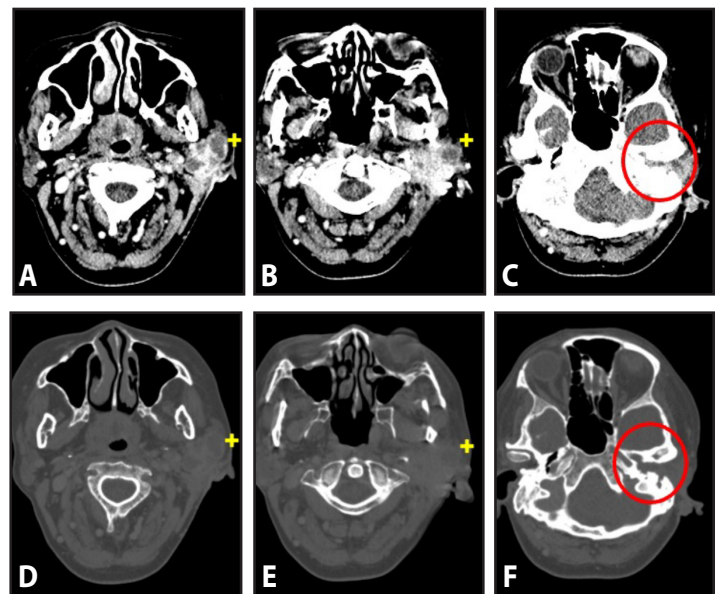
Computed Tomography Scans, axial high resolution: A-C, soft tissue and D-F, bone windows revealing a multiple heterogenous cystic nodule with enhancing wall seen in the left infra-auricular region (+) and soft tissue attenuating fluid collection seen in the left internal auditory canal with associated widening and erosion of the surrounding bone in the middle ear. (encircled)
